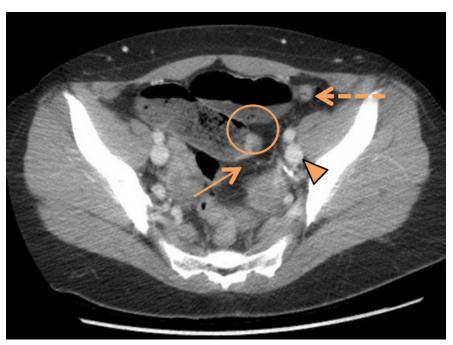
CT abdomen pelvis w/contrast of a small bowel obstruction of in a young woman with a left congenital omental defect. Specific findings include the transition point in the left pelvis (arrowhead), prominent loops of dilated distal ileum with air-fluid levels (dashed arrow), a small bowel feces sign (circled) and adjacent free fluid within the right pelvis (solid arrow).
